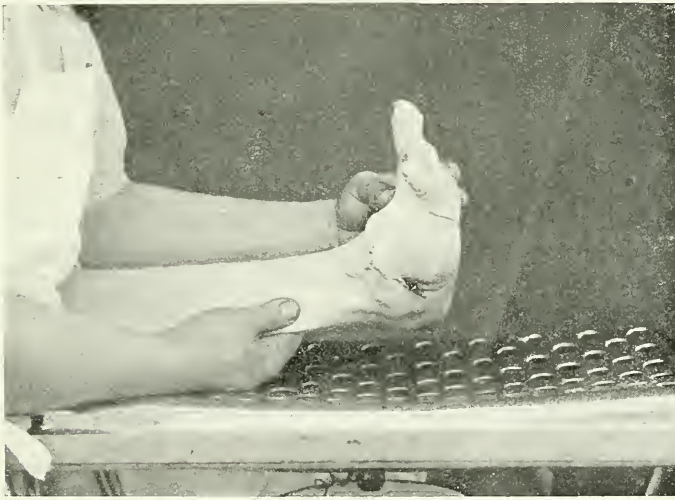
THE SAME. REDUCTION OF THE DEFORMITY: ASPECT OF THE SKIN SUTURE.
